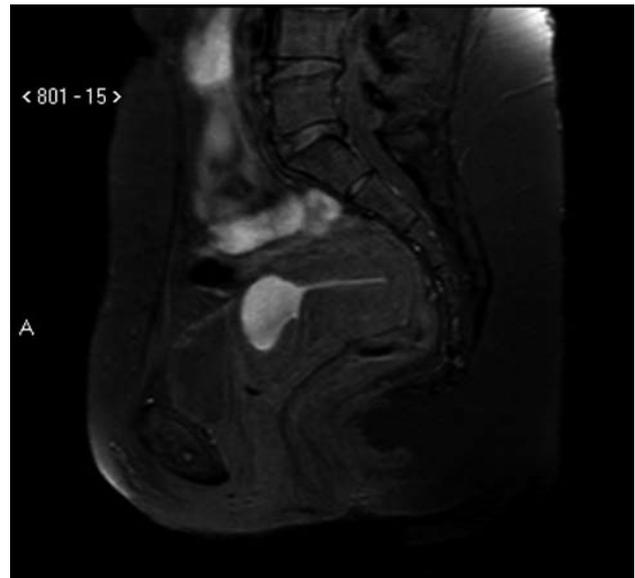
By using T1-weighted images with saturation of fatty tissue, the niche appears inhomogeneously hyperintense (the signal in the declive portion is slightly inhomogeneous and slightly less hyperintense). This feature is suggestive of menstrual blood retention in the niche. A thin hyperintense line is also evident in the uterine cavity suggestive of menstrual blood.
